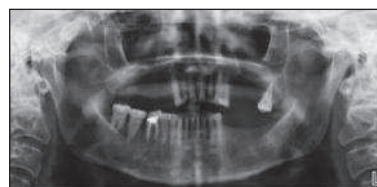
NPDC is seen just above the roots of the anterior maxillary incisors on the panoramic radiography (Case 2).
